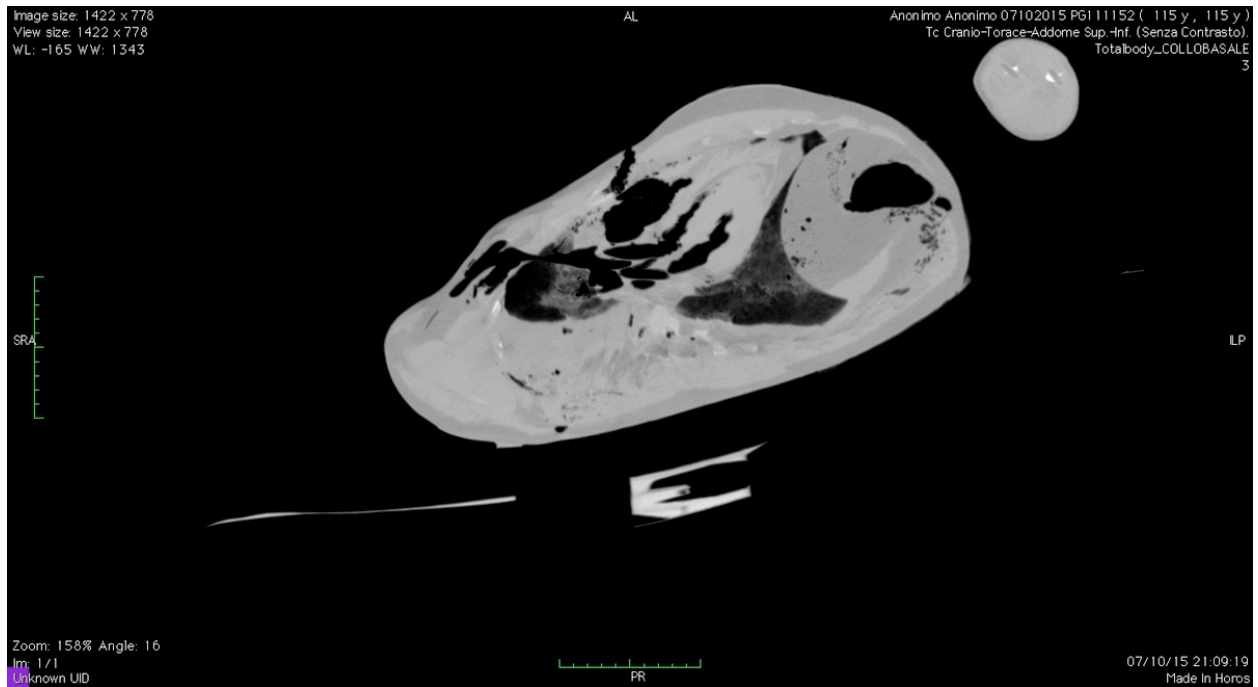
CT oblique MIP reconstruction of bullet trajectory through the chest
